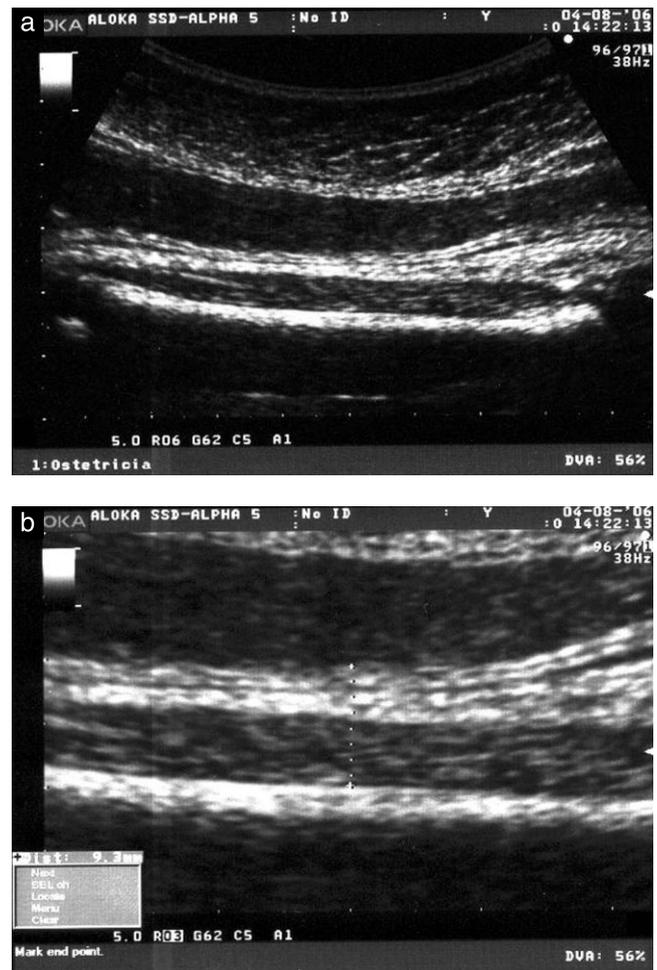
Sonographic measurement technique for fetal mid-thigh soft-tissue thickness. The longitudinal section as used for measuring femur length is obtained (a) and then magnified (b). Calipers are placed on the outer margin of the skin and the outer margin of the femur shaft, with the femur lying parallel to the transducer (b).
